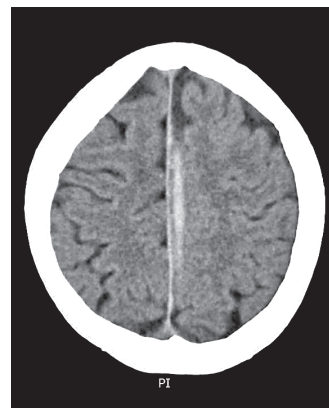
Brain computed tomography – regression of falx cerebri subdural haematoma
